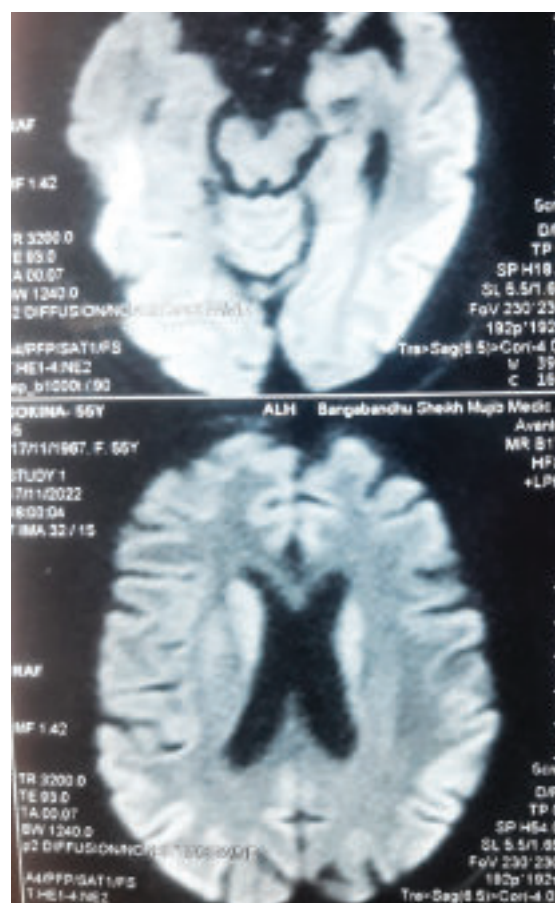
Mild restricted diffusion is observed in both parietal and temporal lobe (left>right) on diffusion weighted imaging of brain MRI
